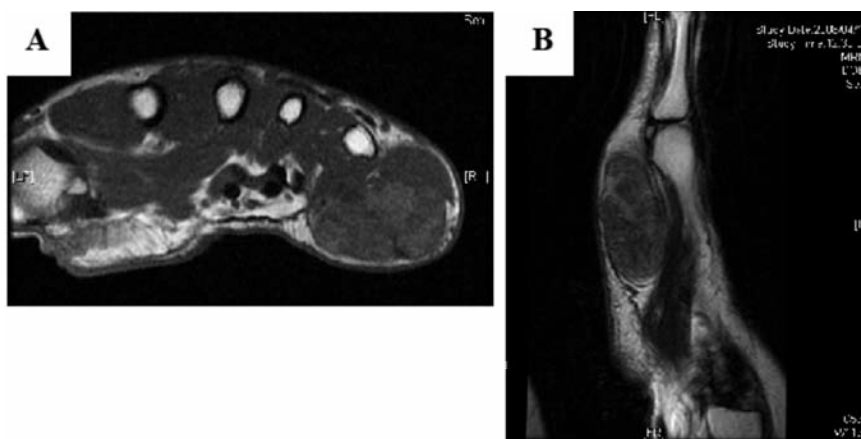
(A) Axial T1-weighted magnetic resonance imaging scan revealing a 4×4×2 cm intermediate intensity mass in the subcutaneous region of the right hand. (B) Sagittal T2-weighted image showing a similar heterogeneous finding. The intensity was slightly higher than in the surrounding muscle.
